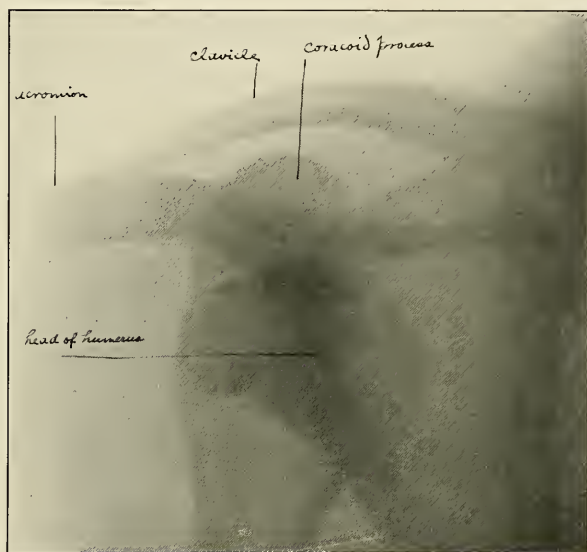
X-ray of a subcoracoid dislocation of the humerus. Note the position of the humeral head, with reference to acromion, coracoid, clavicle, and glenoid cavity. (X-ray taken by Mr. Dodd, Massachusetts General Hospital.)
